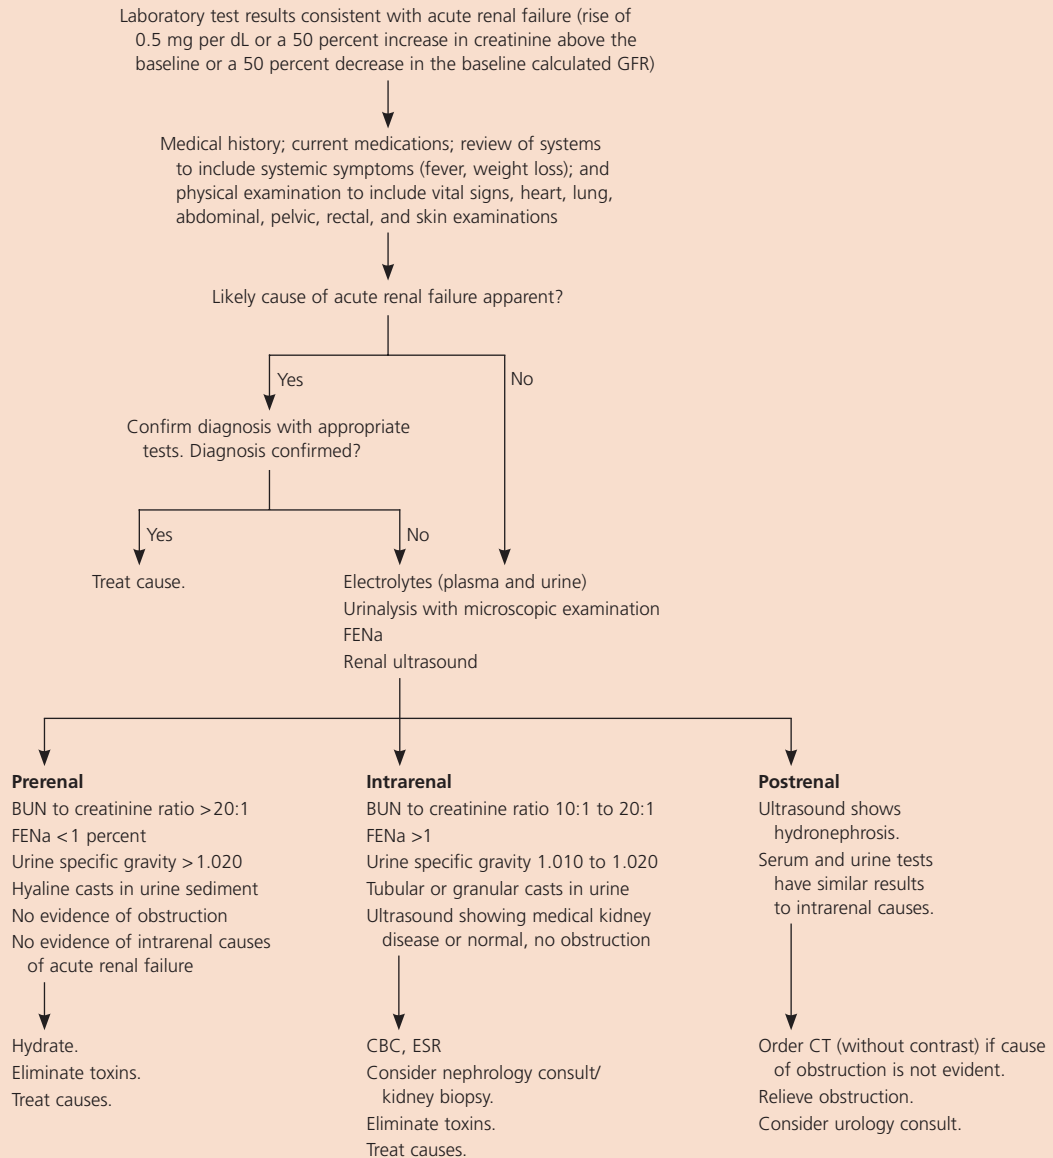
Algorithm for the initial evaluation of acute renal failure. (GFR = glomerular filtration rate; FENa = fractional excretion of sodium; BUN = blood urea nitrogen; CBC = complete blood count; ESR = erythrocyte sedimentation rate; CT = computed tomography.)
